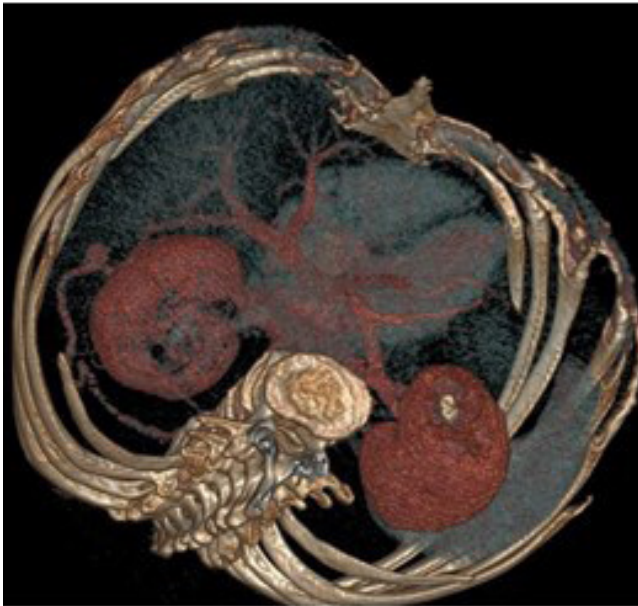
3D CT angiogram shows the abnormal venous drainage of the right kidney.
